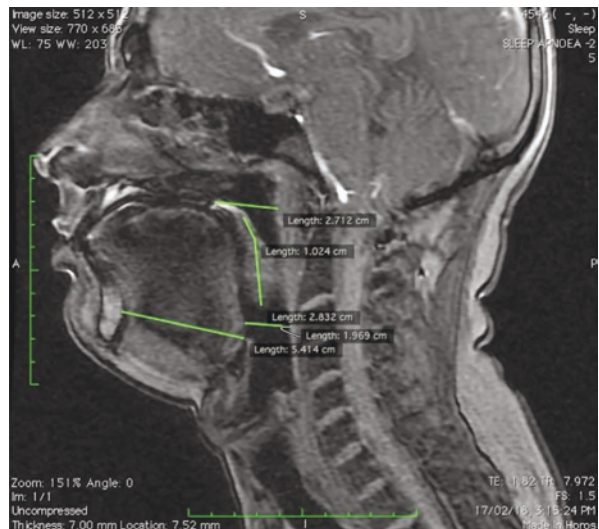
Dynamic MRI of an OSAS patient showing adenoidal hypertrophy
